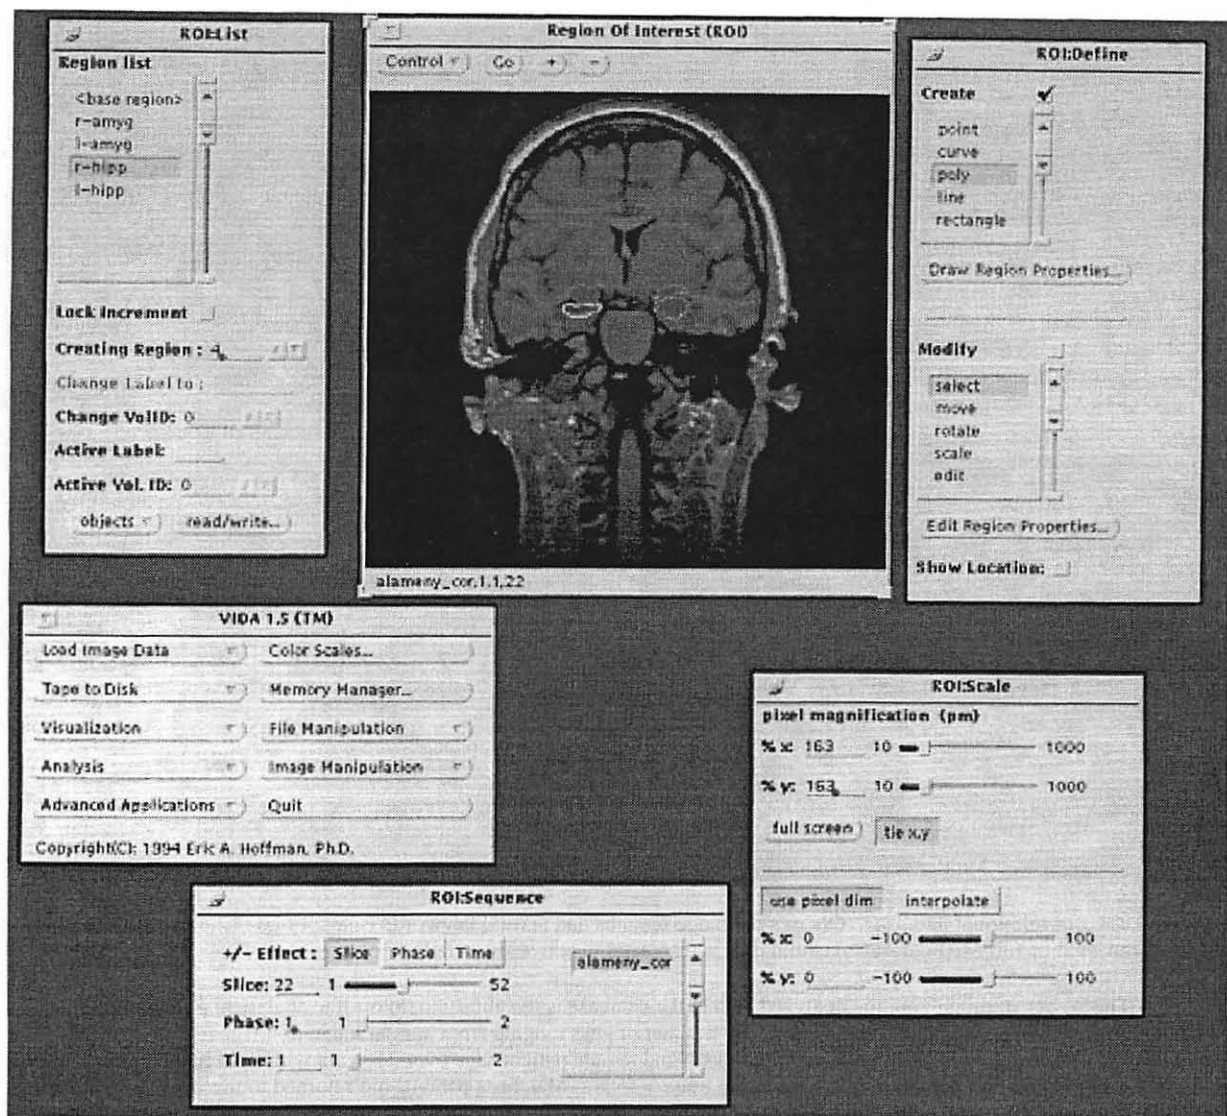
A screenshot taken from the multimedia PACS workstation showing the interactive segmentation of temporal lobe structures from MR images.
